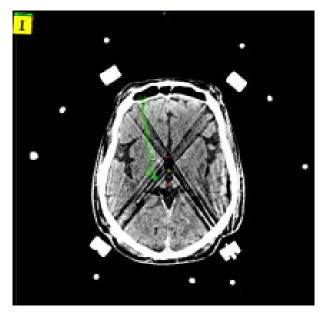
Axial CT brain with ring and fiducial marks for planning in Stereocheck.
